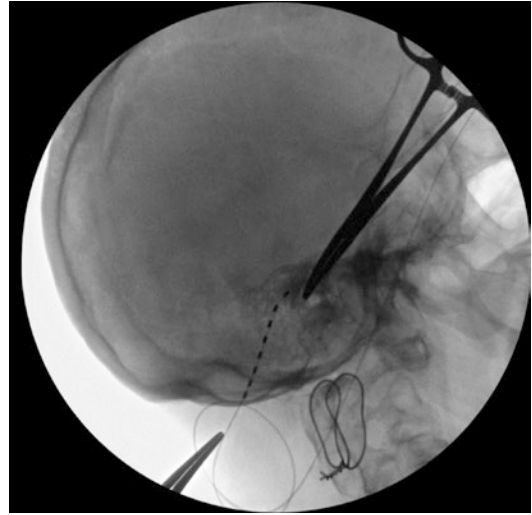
Intraoperative x-ray for placement of lead for unilateral occipital nerve stimulation
